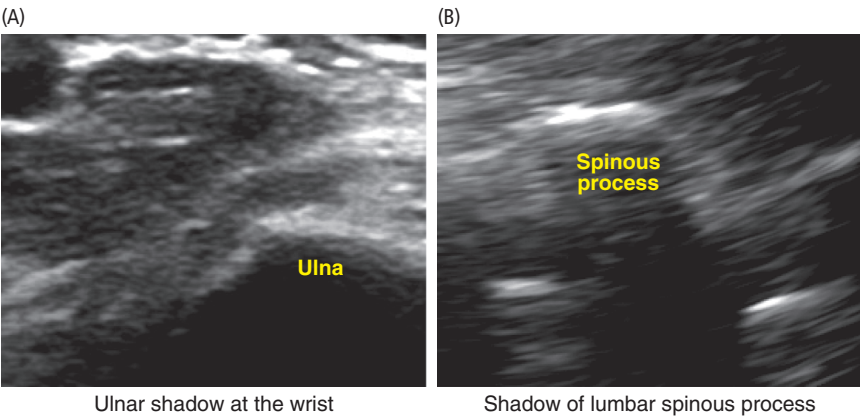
Bone profiles and drop-out shadows in an ultrasound scan
